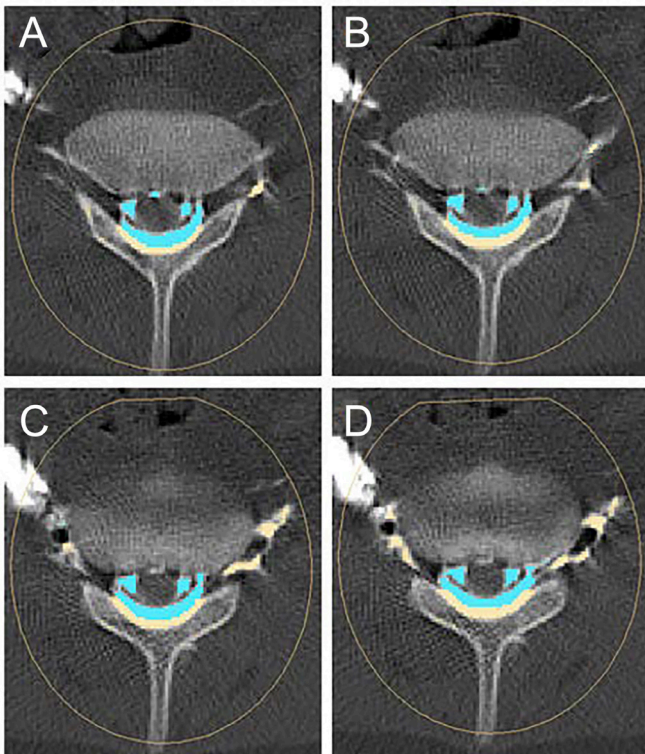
Cross-sectional view of the CT. CT scan image sequence, as an example of four consecutive slices (cranial to caudal) in which epidural and intrathecal contrast were segmented. We followed the principle of the continuity of the structures to segment the contrast fluid in the epidural area (blue corresponds to the contrast medium within the subarachnoid space and yellow represents the epidural space filled with epidural fat). The colors in the surface of the images were modified using Adobe Photoshop (Adobe, San Jose, California, USA). The texture was kept and color was added to make the images easier to understand.
